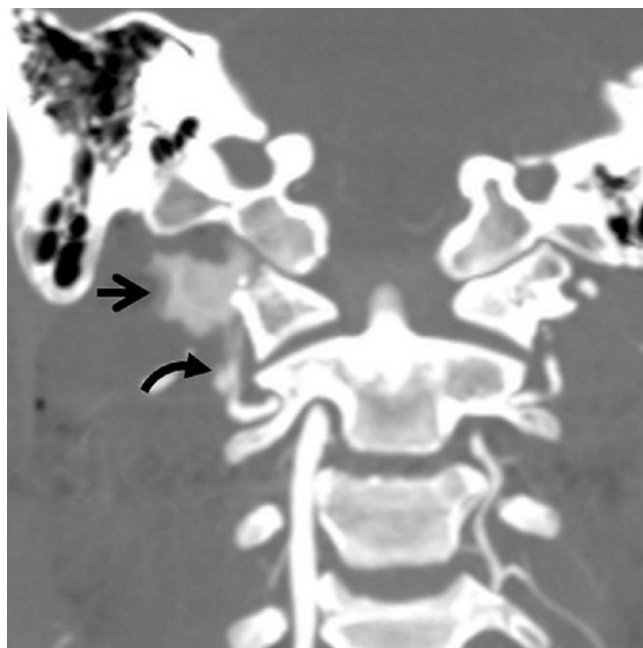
Grade V vertebral artery injury. Coronal reconstructed CTA of patient with severe closed neck injury demonstrates transection of right vertebral artery (curved arrow) at C1–C2 with active contrast extravasation (arrow)
